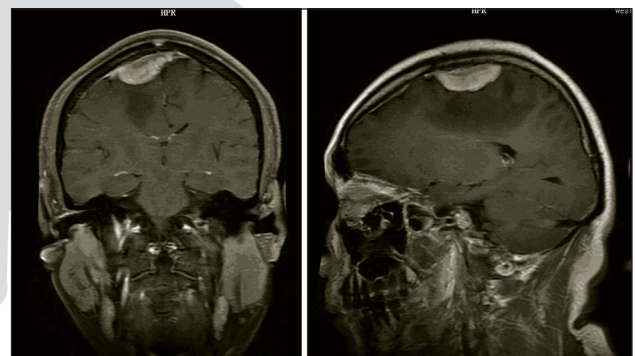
B MRI revealed there was no significant change of the mass at 24 months follow-up after Gamma Knife treatment.
